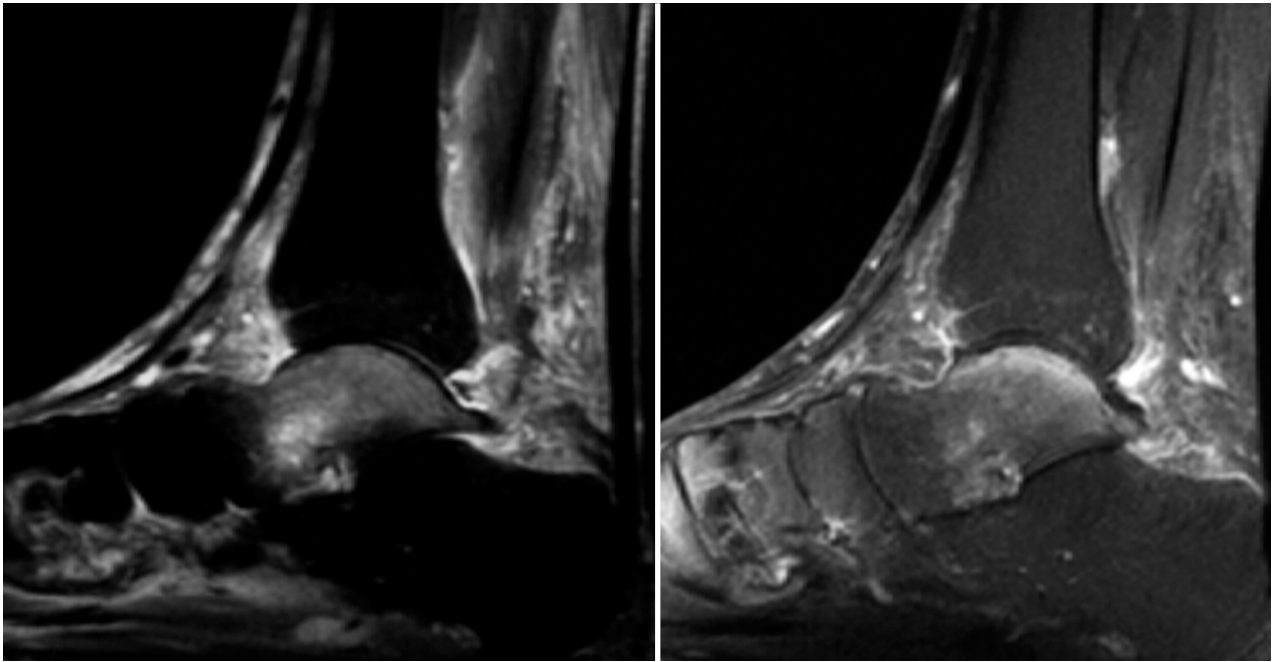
a and b. Baseline MRI (left foot) of a 76 year old patient with idiopathic neuropathy who presented with symptoms of CA (soft tissue edema, pain, and elevated skin temperature of the left foot). Imaging findings include a strong edema in the trabecular bone of the talus and high signal intensity within the soft tissues around the ankle. Contrast enhancement was present in the whole talus, which was most pronounced in the subchondral area.
